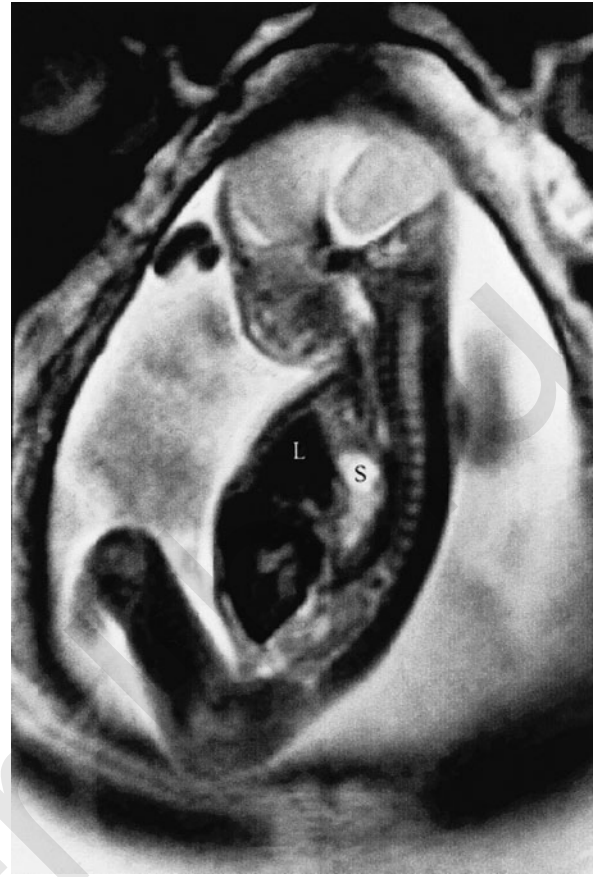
Magnetic resonance imaging of a congenital diaphragmatic hernia showing liver (L) and stomach (S) in the chest.
